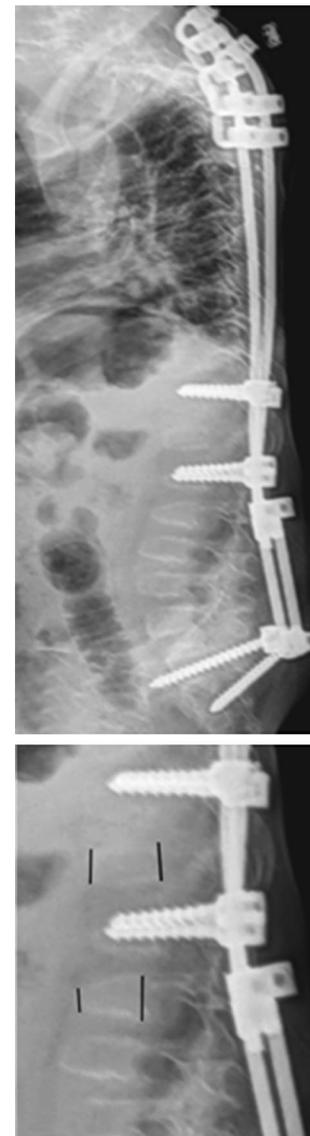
A sagittal X-ray scan for a patient with thoracolumbar kyphosis before he underwent the surgery. The lines represent the anterior and posterior vertebral body heights preoperatively for L1 (6.8 and 10.32 mm), respectively, and for L3 (5.39 and 11.27 mm), respectively
